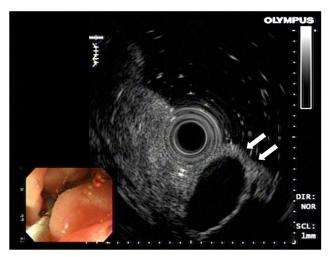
Endoscopic ultrasound of the lesion. A hypoechoic homogenous lesion is located at the submucosal layer (white arrows).
